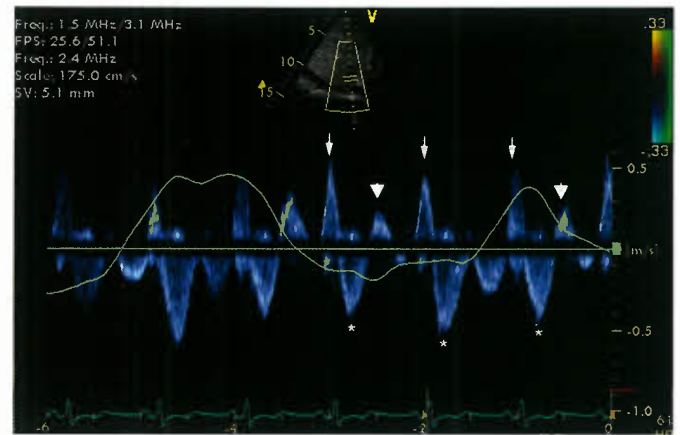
Pulsed Doppler sampled in the hepatic vein of a patient with hypertrophic cardiomyopathy. Respirometry is seen in green. Findings are consistent with restrictive features with systolic antegrade flow (asterisks), retrograde flow in early diastole (arrowheads), and marked flow reversal after atrial contraction (arrows). In this patient these abnormalities are present during inspiration and expiration.
